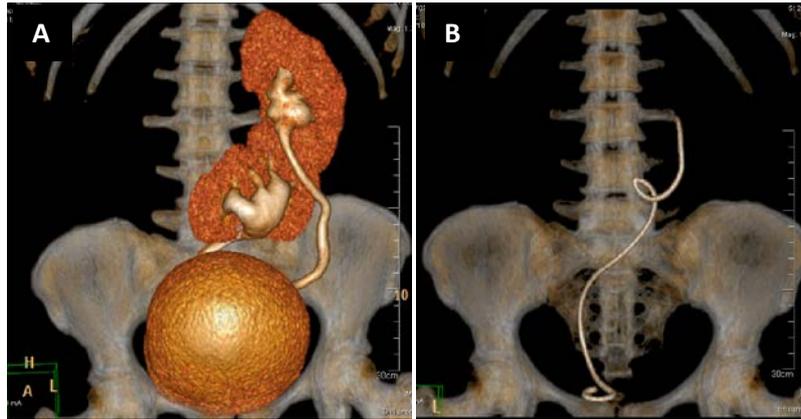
Right-left ERC Fusion (lower RE). Man of 36 years with a history of left ureteral lithiasis and endourology resolved by double-J catheter placement (A) Reconstruction of Volumetric CT observed in the fusion of the upper pole of the lower pole RE with orthotopic kidney. (B) Double J catheter in the left collecting system.
